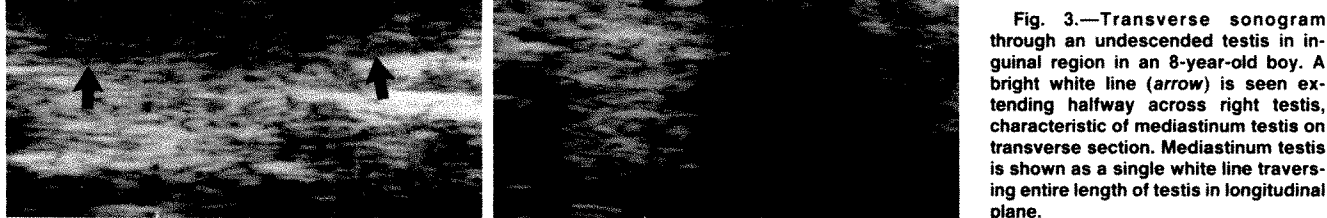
Transverse sonogram through an undescended testis in inguinal region in an 8-year-old boy. A bright white line (arrow) is seen extending halfway across right testis, characteristic of mediastinum testis on transverse section. Mediastinum testis is shown as a single white line traversing entire length of testis in longitudinal plane.
